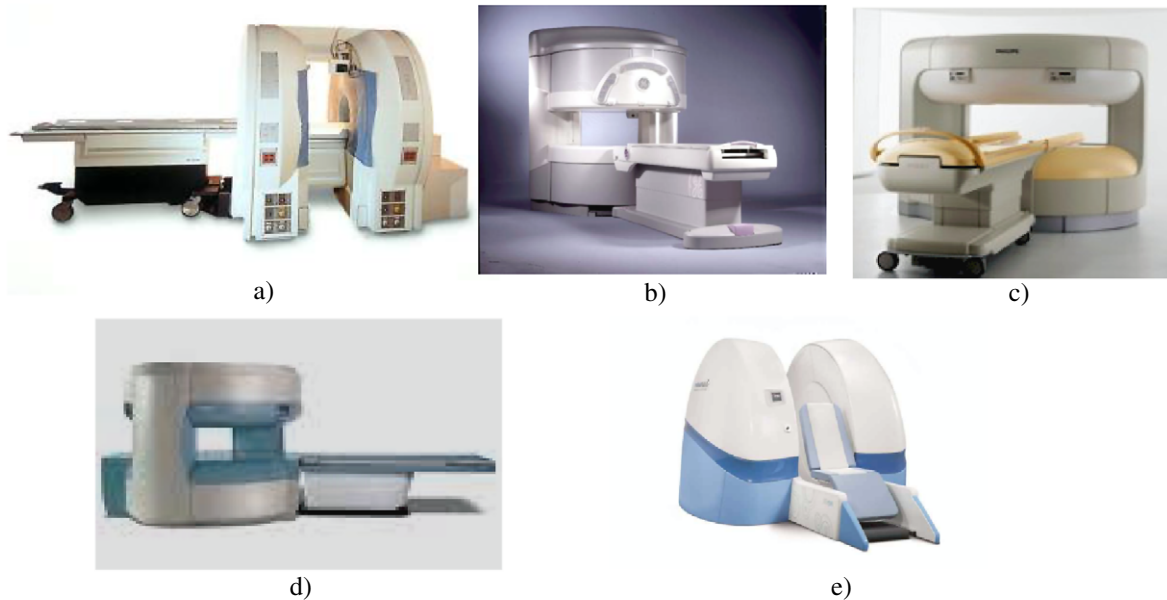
Split-open WB superconducting MRI scanners: (a) 0.5 T Signa-SP interventional (GE); (b) 0.7 T OpenSpeed (GE); (c) 1.0 T Panorama (Philips); (d) 1.2 T Oasis (Hitachi); (e) MgB₂-based 0.5 T OpenSky (Paramed).
